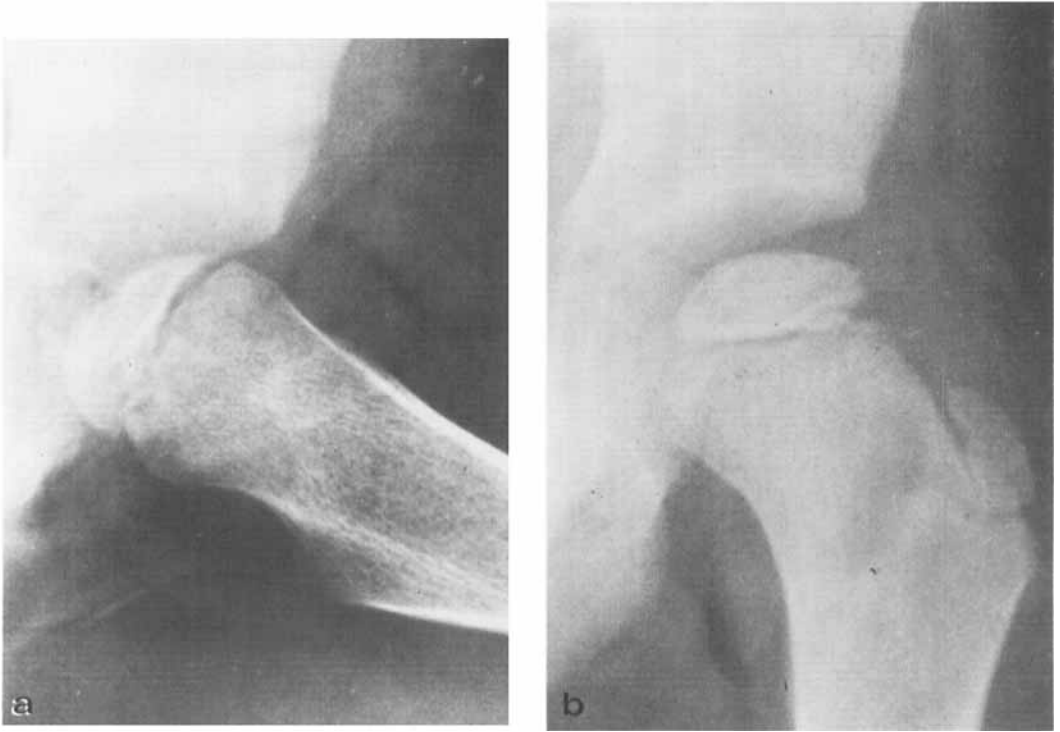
a, b. P.B., 7-year-old boy. Duration of symptoms: 4 weeks. Radiographs taken when the diagnosis was made.
